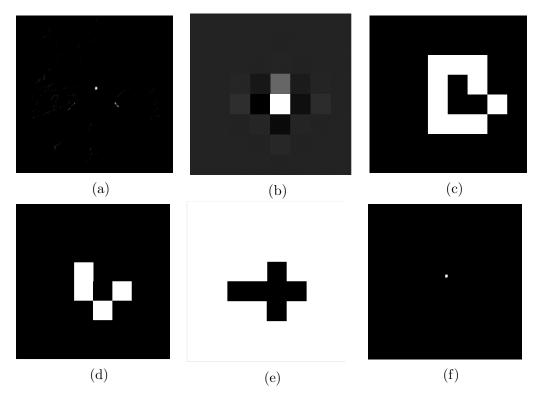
The resulted images of each intermediate step in the proposed algorithm: (a) 512x512 original 2D image (b) 8x8 lowpass subband 2D image after applying the CT decomposition (c) 8x8 constrained 2D image after applying the canny edge operator (d) 8x8 initial segmented 2D image after applying the k-means clustering technique (e) 8x8 HMRF-EM (f) 512x512 final segmented 2D image after applying ICT reconstruction
